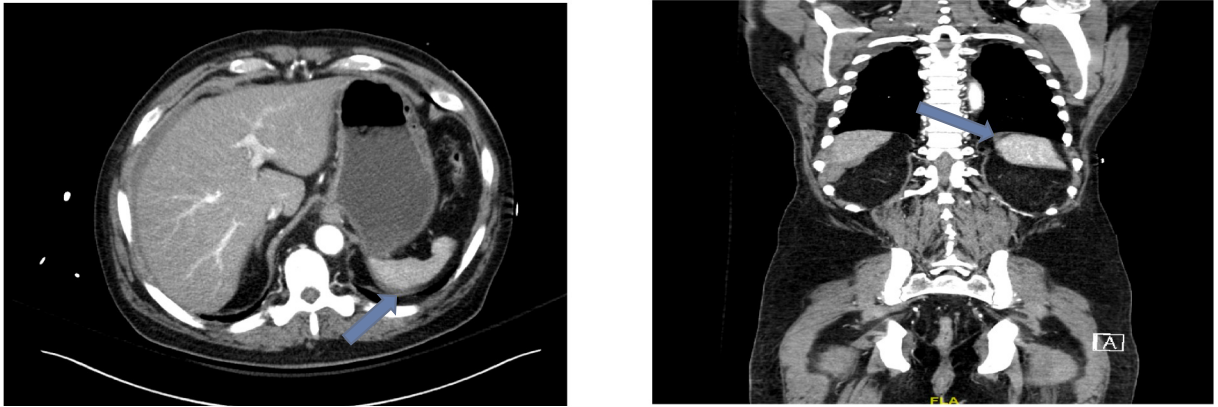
Contrast-enhanced CT scans demonstrating peri-splenic hematoma (see arrows). Spleen unremarkable.
